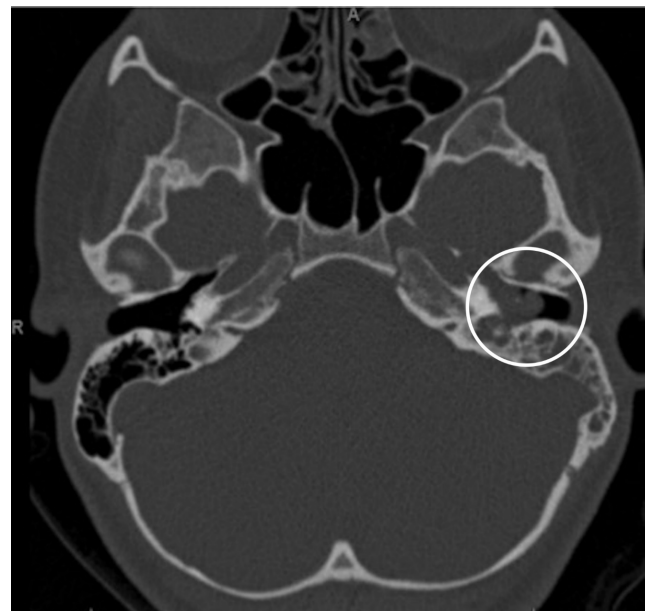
Axial-cut CT Showing Left Middle Ear Mass
